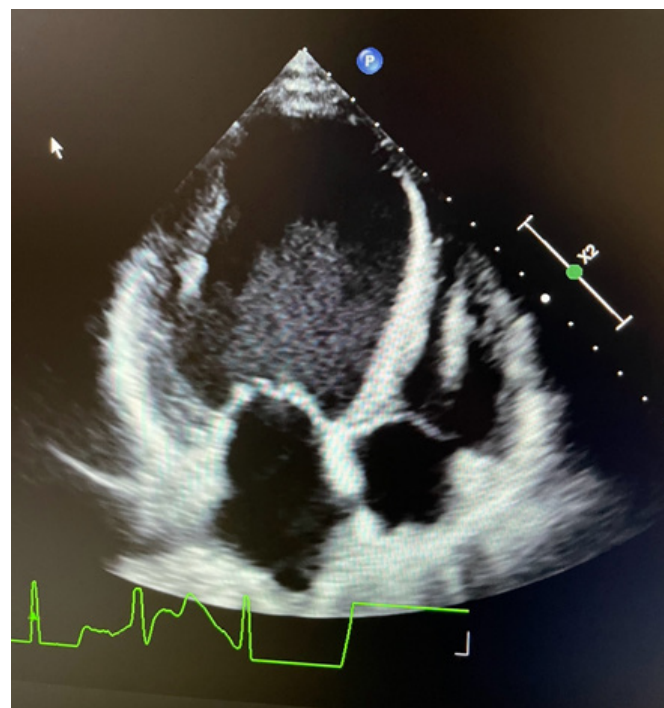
Echocardiography performed when she was admitted to the general intensive care unit
